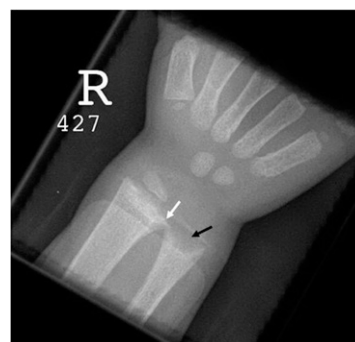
Wrist radiograph shows metaphyseal flaring at the distal end of both the radius and ulna (white arrow) as well as significant cupping of the distal ulnar metaphysis (black arrow).
